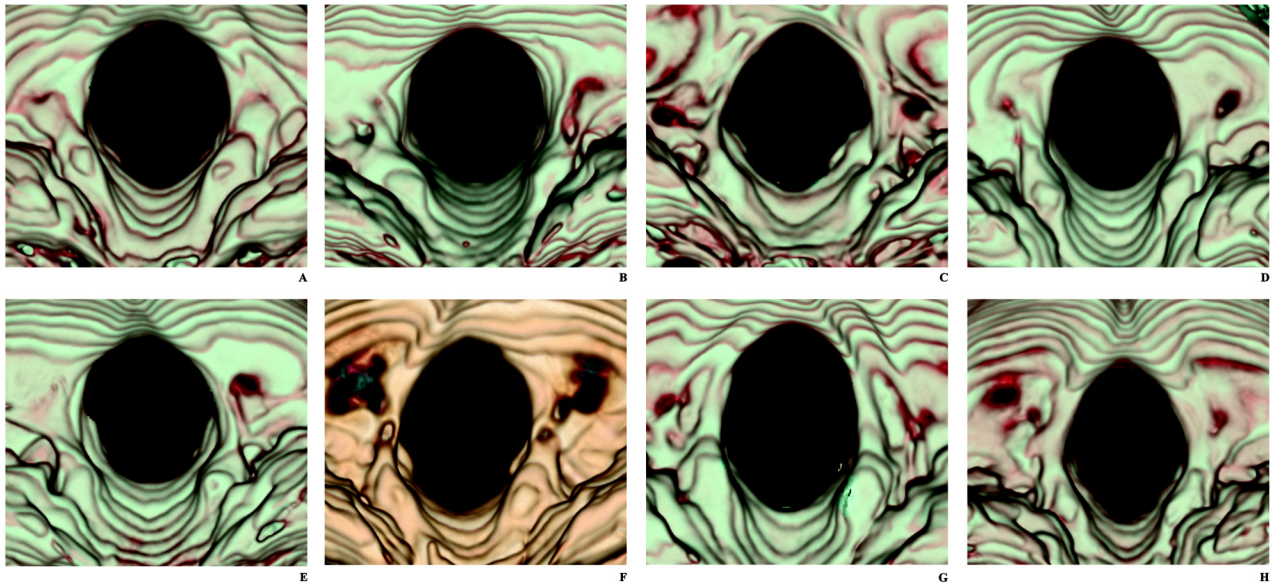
Developmental variances of the contour/shape of foramen magnum: circular (A), two-semicircular (B), heart-like (C), wide oval (D), bi-rounded oval (E), ventrally wide oval (F), bi-pointed oval (G) and dorsally convergent oval (H). Pseudo-3D computed tomography reconstruction imaging of human skulls.
